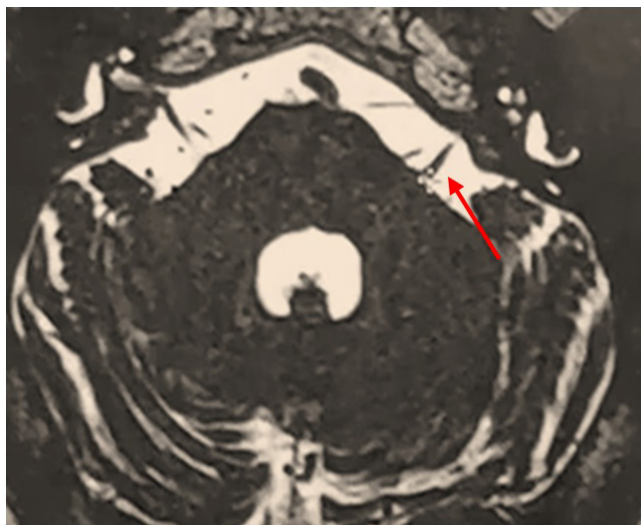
3T HR Axial MRI-T2W 3D Sequence showing Vascular Looping in the 7th/8th Nerve Complex on Left.
